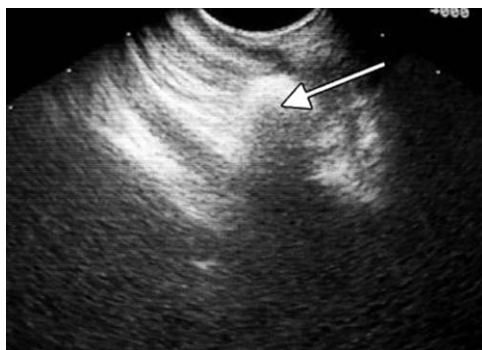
Endoscopic ultrasound image of the OncoGel™ injection site (arrow). Reproduced from ref. 21 with permission from Thieme, © Georg Thieme Verlag KG.
